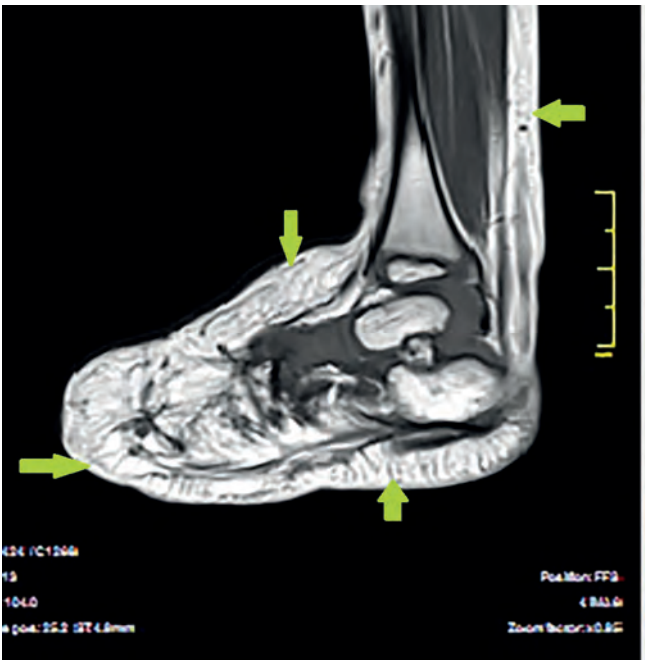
Sagittal T1 weighted MR images; thickening in the fatty tissue is shown, especially over the foot.
